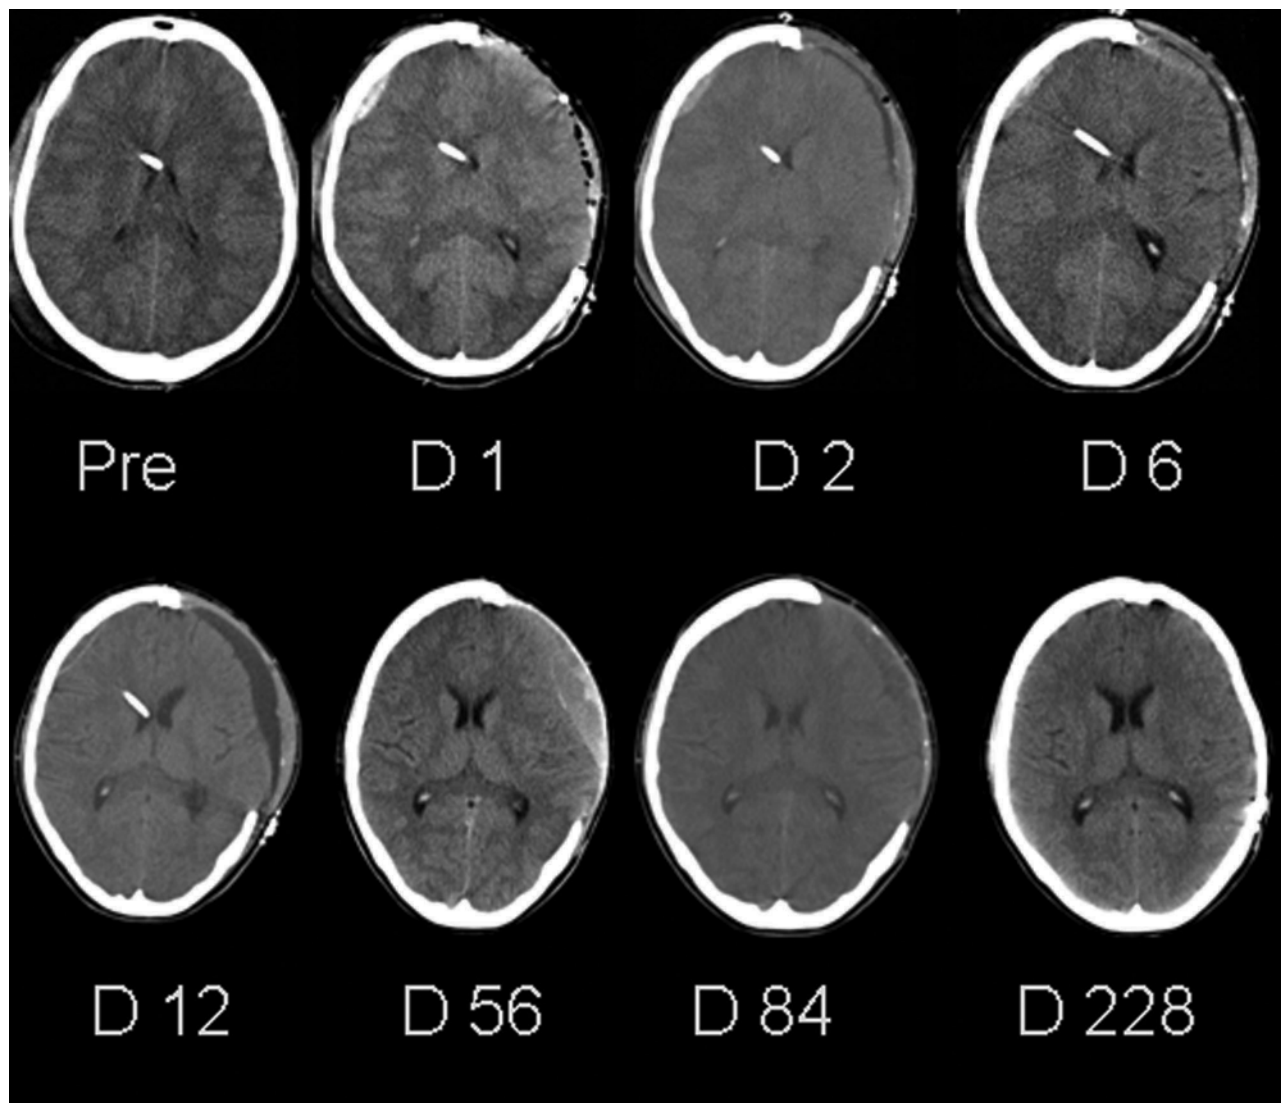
Three days after her admission, this 16-year-old girl experienced sustained ICP of 31.8 mm Hg for which she underwent DC. A follow-up CT scan indicated the first evidence of an SDG on Day 2 (D2) after DC. Although her condition was clinically stable, a head CT obtained on Day 56 (D56) showed evidence of internal bleeding. The SDH gradually disappeared, and she had cranioplasty on Day 228. Thirty-one months after the injury she was asymptomatic with a GOS score of 5.
